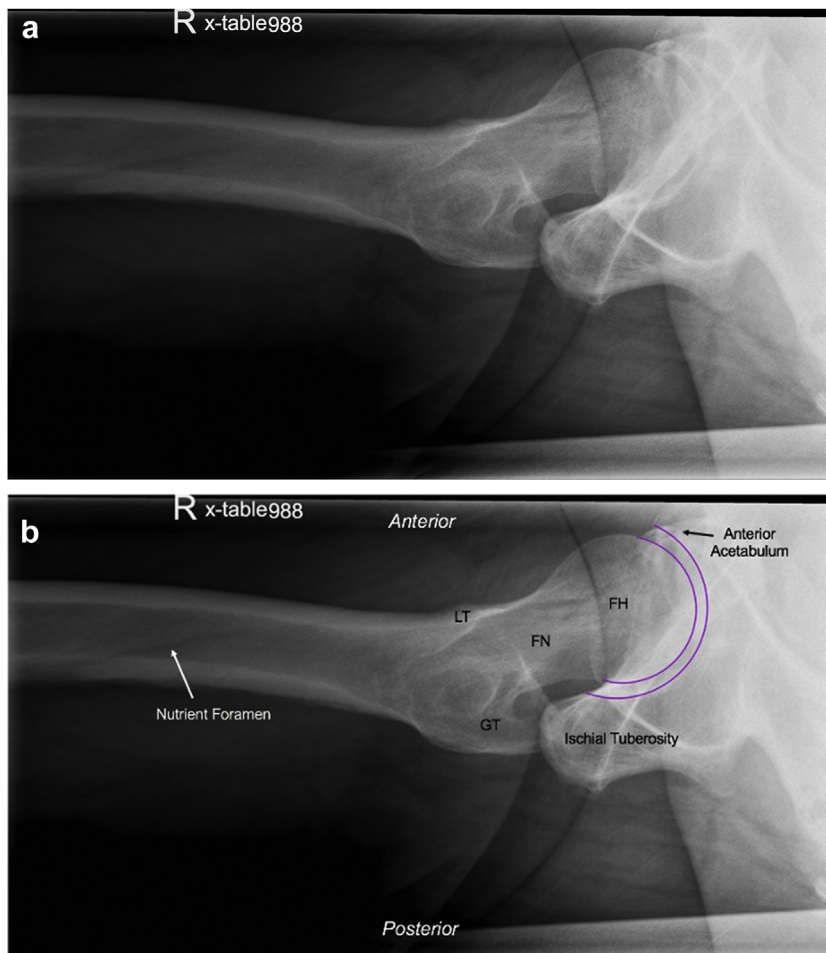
Direct lateral radiograph. Unlabeled (a) and labeled (b). FH, femoral head; FN, femoral neck; LT, lesser trochanter; GT, greater trochanter; purple lines denote the hip joint space.
